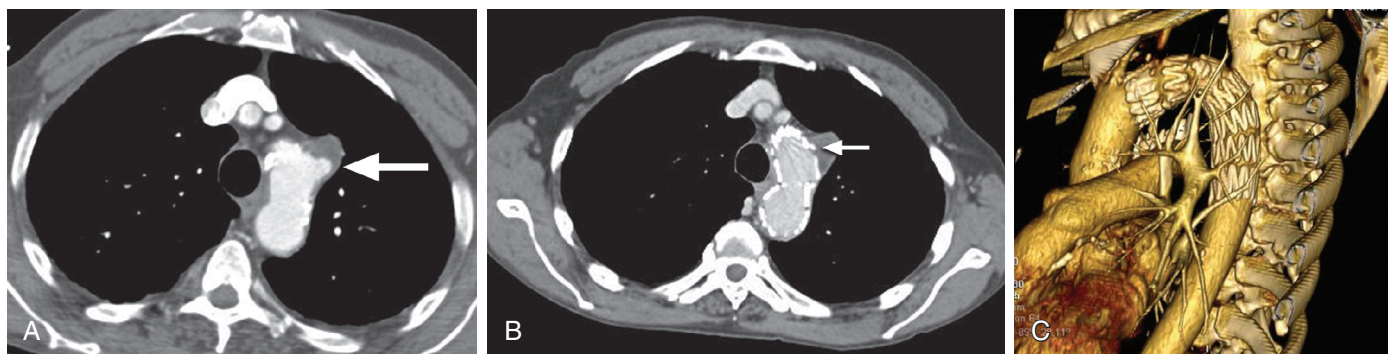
FIGURE e57-24 A, Contrast-enhanced CT scan demonstrating an acute PAU with a focal pseudoaneurysm (*arrow*) involving the proximal descending aorta. The aorta is heavily calcified. B, Contrast-enhanced CT scan after endovascular repair of a symptomatic PAU (*arrow*). C, Three-dimensional CT reconstruction after repair of the PAU previously demonstrated in A and B.
